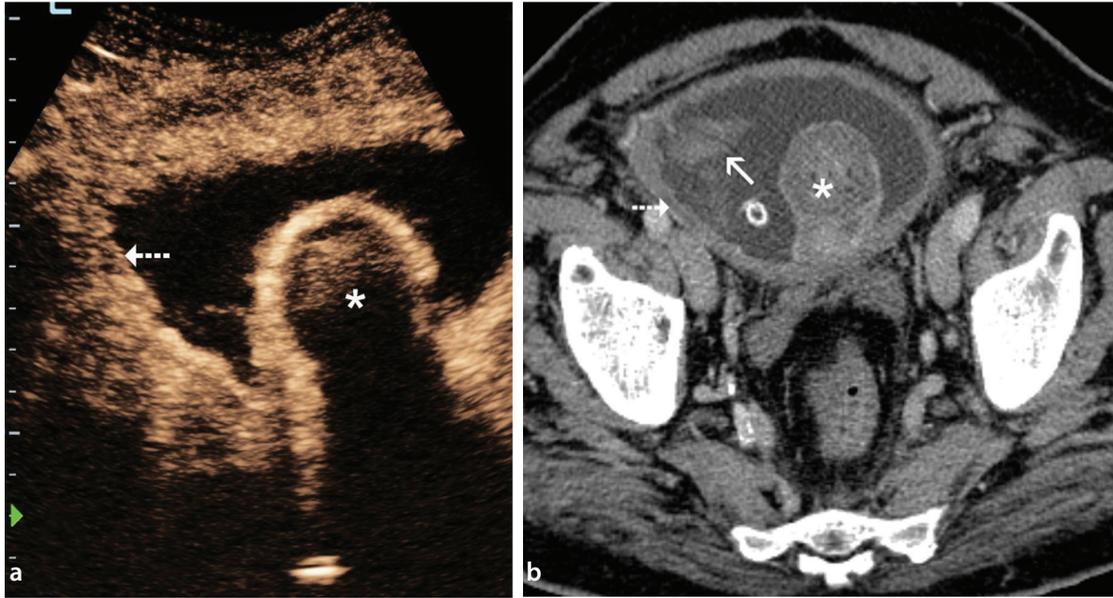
Representative images from a complicated case of prostatic artery embolization (PAE) with TGM 40–120. Three days post-PAE, axial contrast-enhanced ultrasonography image (a); shows extensive infarction (*) of a large intravesical prostatic protrusion. A small area of reduced enhancement is suspected in the right lateral bladder wall (dotted arrow). Axial contrast-enhanced computed tomography image (b); performed immediately thereafter, also shows prostatic infarction (*), along with hypoenhancement (dotted arrow) and irregularity of the right lateral bladder wall. An irregularly shaped intraluminal mass (arrow) corresponds to sloughed necrotic superficial layers of the bladder wall, as confirmed by cystoscopy (images not shown).
